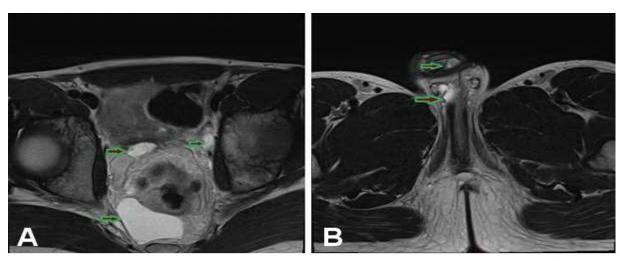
A) Multispacial perirectal LM involving the pelvic peritoneum and soft tissues adjacent to the coccyx, initial MRI. B) Microcystic LM with extent in the corpora cavernosa and spermatic cord, initial MRI.
